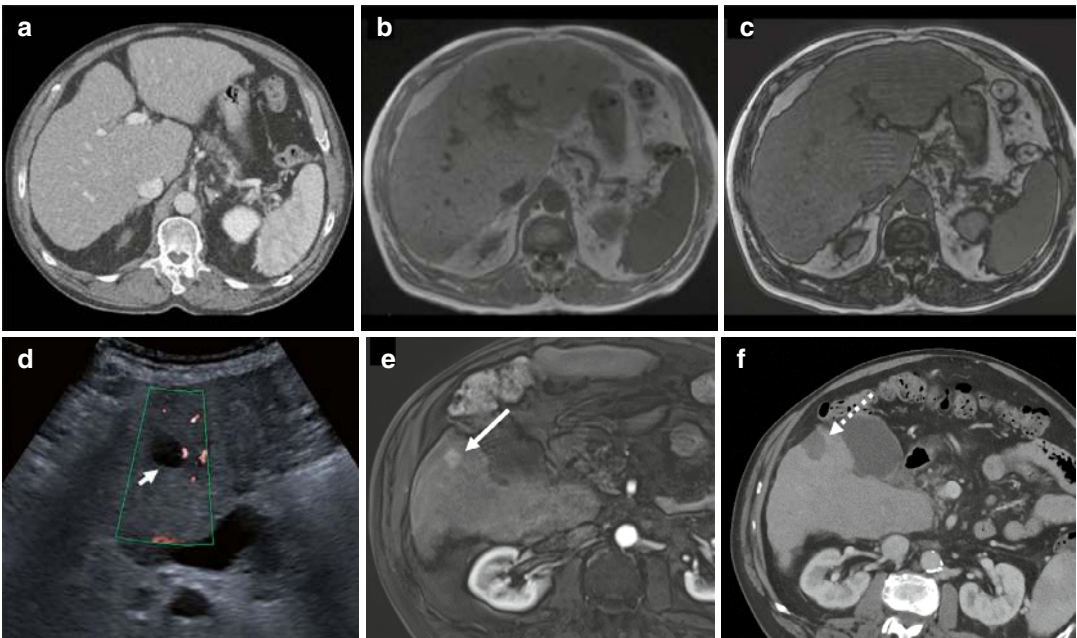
(a) Axial CT demonstrating a dysmorphic liver with an undulating contour and enlarged caudate lobe. (b) and (c) In- and opposed-phase MRI shows diffuse steatosis and micronodular change. (d) US surveillance detected a
